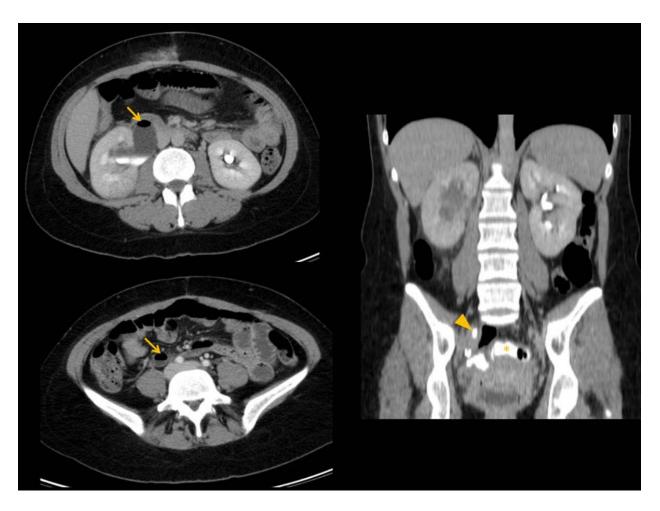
Patient with complicated ovarian cyst removal by laparoscopy. Contrastenhanced CT scan obtained at the level of the kidneys shows ureterohydronephrosis and air within the right ureter (arrows). The most distal portion of the ureter (arrowhead) communicates via thin fistulous tract with the sigmoid, causing the appearance of iodine contrast in the sigmoid (*) - iatrogenic ureterosigmoid fistula.
